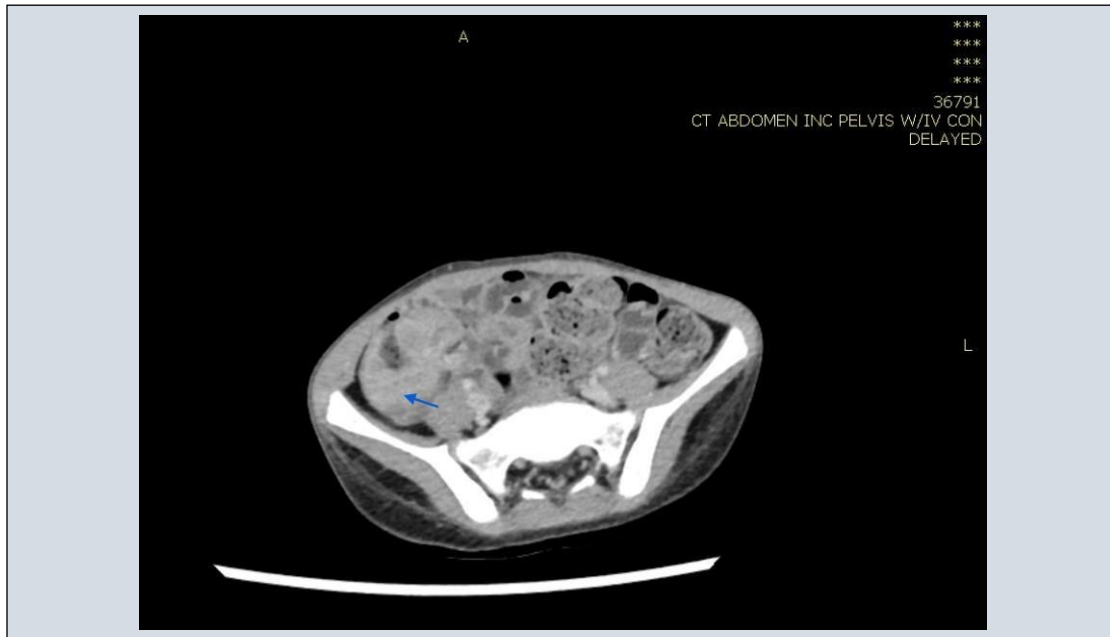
CT scan of the abdomen with iv contrast showed the liver is enlarged, showing large ill defined mass lesion of the medial segment of the left hepatic lobe, the lesion is about 6 cm this lesion is mildly hypodense to isodense (red arrow), there is another similar lesion at the right lobe about 3.6 cm, there are associated pathologic significantly enlarged lymph nodes at the porta hepatis and peripancreatic head region about 2.3 cm in short diameter. The caecum and proximal ascending colon are presenting segment of circumferential moderate wall thickening about 5 cm with significant submucosal oedema and lumen narrowing (blue arrow), multiple significantly enlarged mesenteric lymph node largest about 1.5cm in short diameter and 2.3cm in long diameter, conclusion large two focal lesions of the right and left hepatic lobes, associated circumferential thickening and oedema of the caecum and proximal ascending colon, pathologic enlarged necrotic lymph node at the porta hepatis and bowel mesentery. The described finding are suggestive of infection with special attention for fungus infection, especially Gastrointestinal Basidiobolomycosis.
